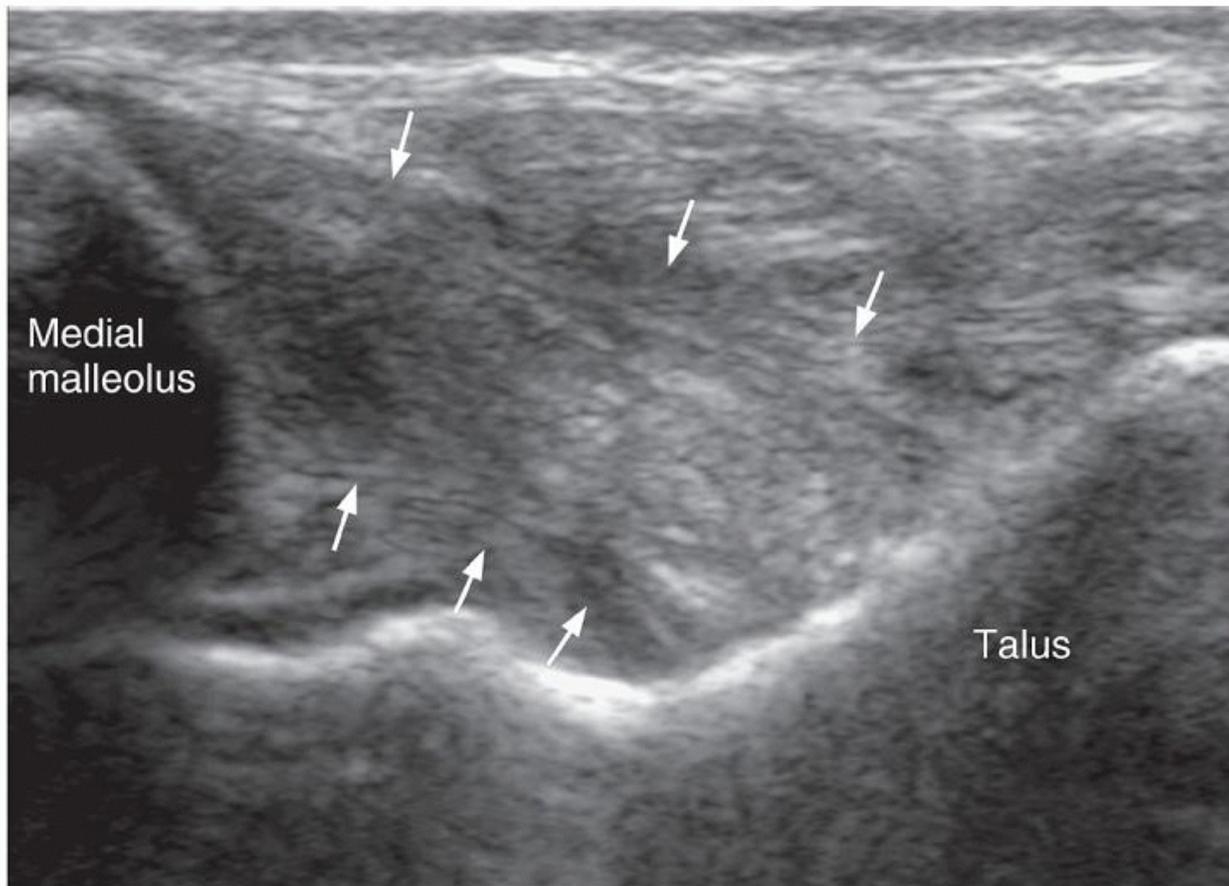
Longitudinal ultrasound showing normal fan-shaped deltoid ligament. The five different components of the deltoid ligament (arrows) are not readily distinguishable on ultrasound. The posterior fibers of the ligament extending between the medial malleolus and the talus are shown.
